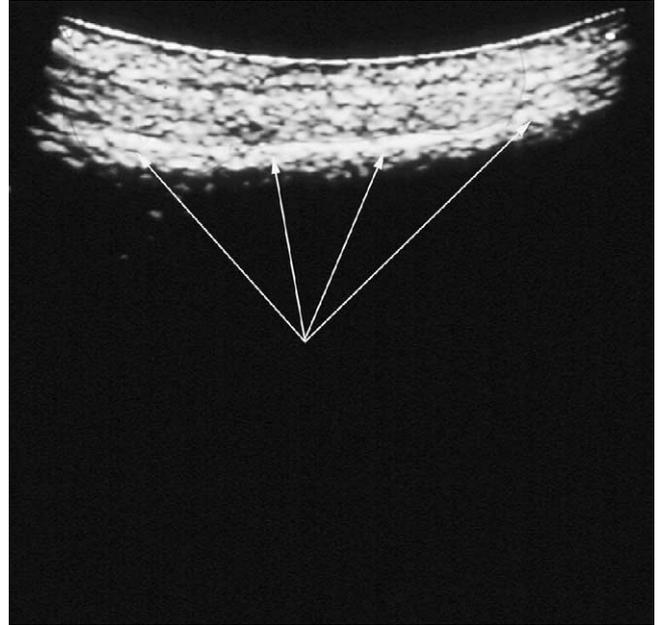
Ultrasound image of the normal anatomy of the lateral orbital wall. The arrows show the convex structure of the lateral orbital wall.
